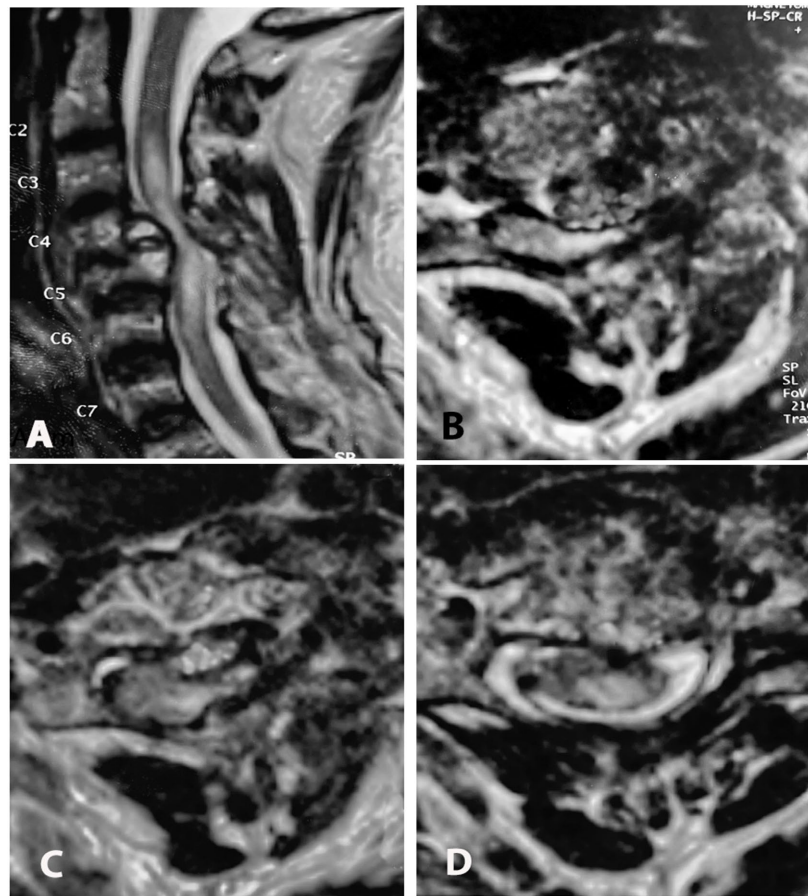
(A) Sagittal T2-weighted Magnetic Resonance Imaging (MRI) of the cervical spine demonstrating a severe compressive fracture of C5 with a posterior wall expelled bone fragment located behind C4 and compressing the spinal cord. Extensive left side edema of the spinal cord is evident. Note the increase in signal intensity of the expelled bone fragments. (B) Axial T2-weighted section of C5 confirms the left-sided spinal cord compression with severe edema that extends both (C) rostrally and (D) caudally in the spinal cord.
